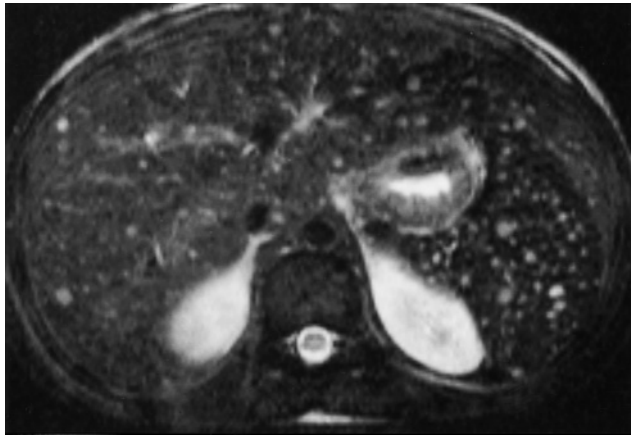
Hepatosplenic candidiasis. T2-weighted fat-suppressed echo-train spin-echo image demonstrates multiple, well-defined, high-signal-intensity candidiasis abscesses <1 cm in the liver and spleen.
